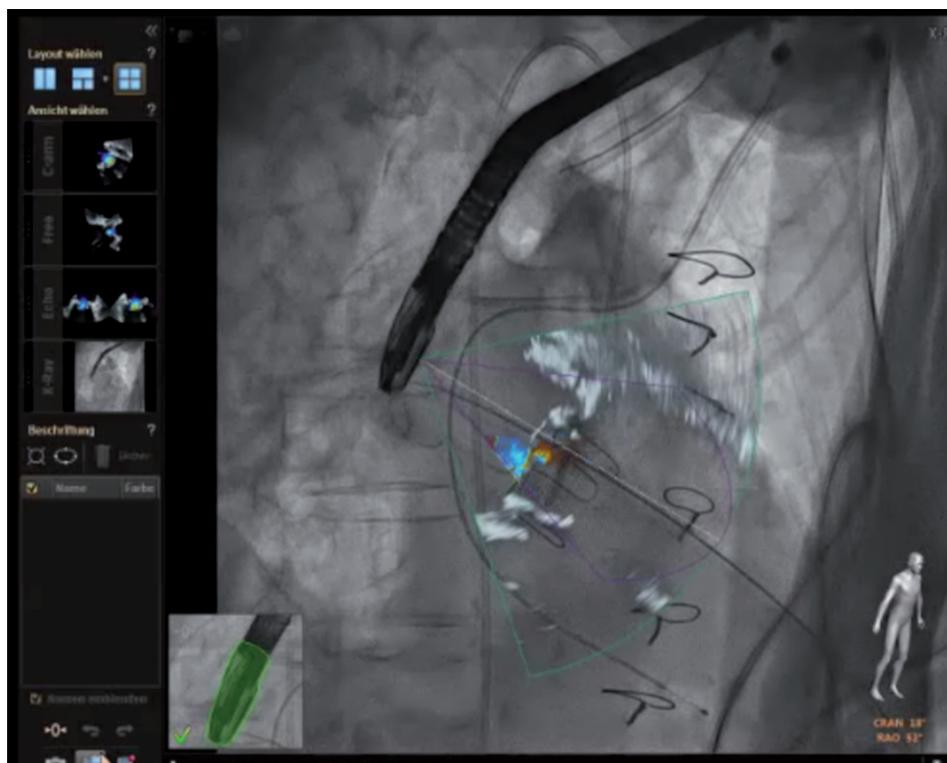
Hybrid/fusion imaging during paravalvular regurgitation closure. After coregistration of the transesophageal echocardiographic probe with the fluoroscopic image, the two images can be fused to allow a more comprehensive understanding of anatomy. Localizing the regurgitant orifice on transesophageal echo imaging can then be translated to the corresponding position on the fluoroscopic image.
